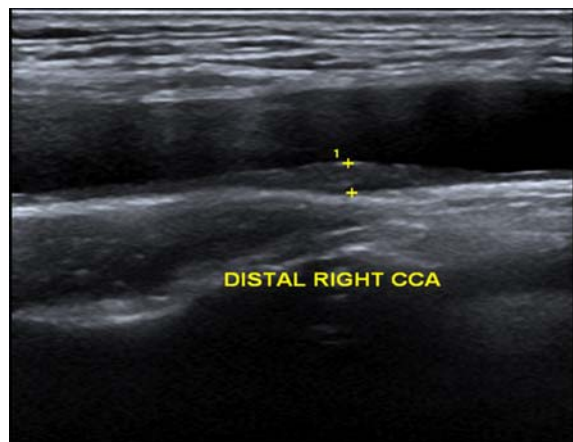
Ultrasound (US) example of an isoechoic plaque.
